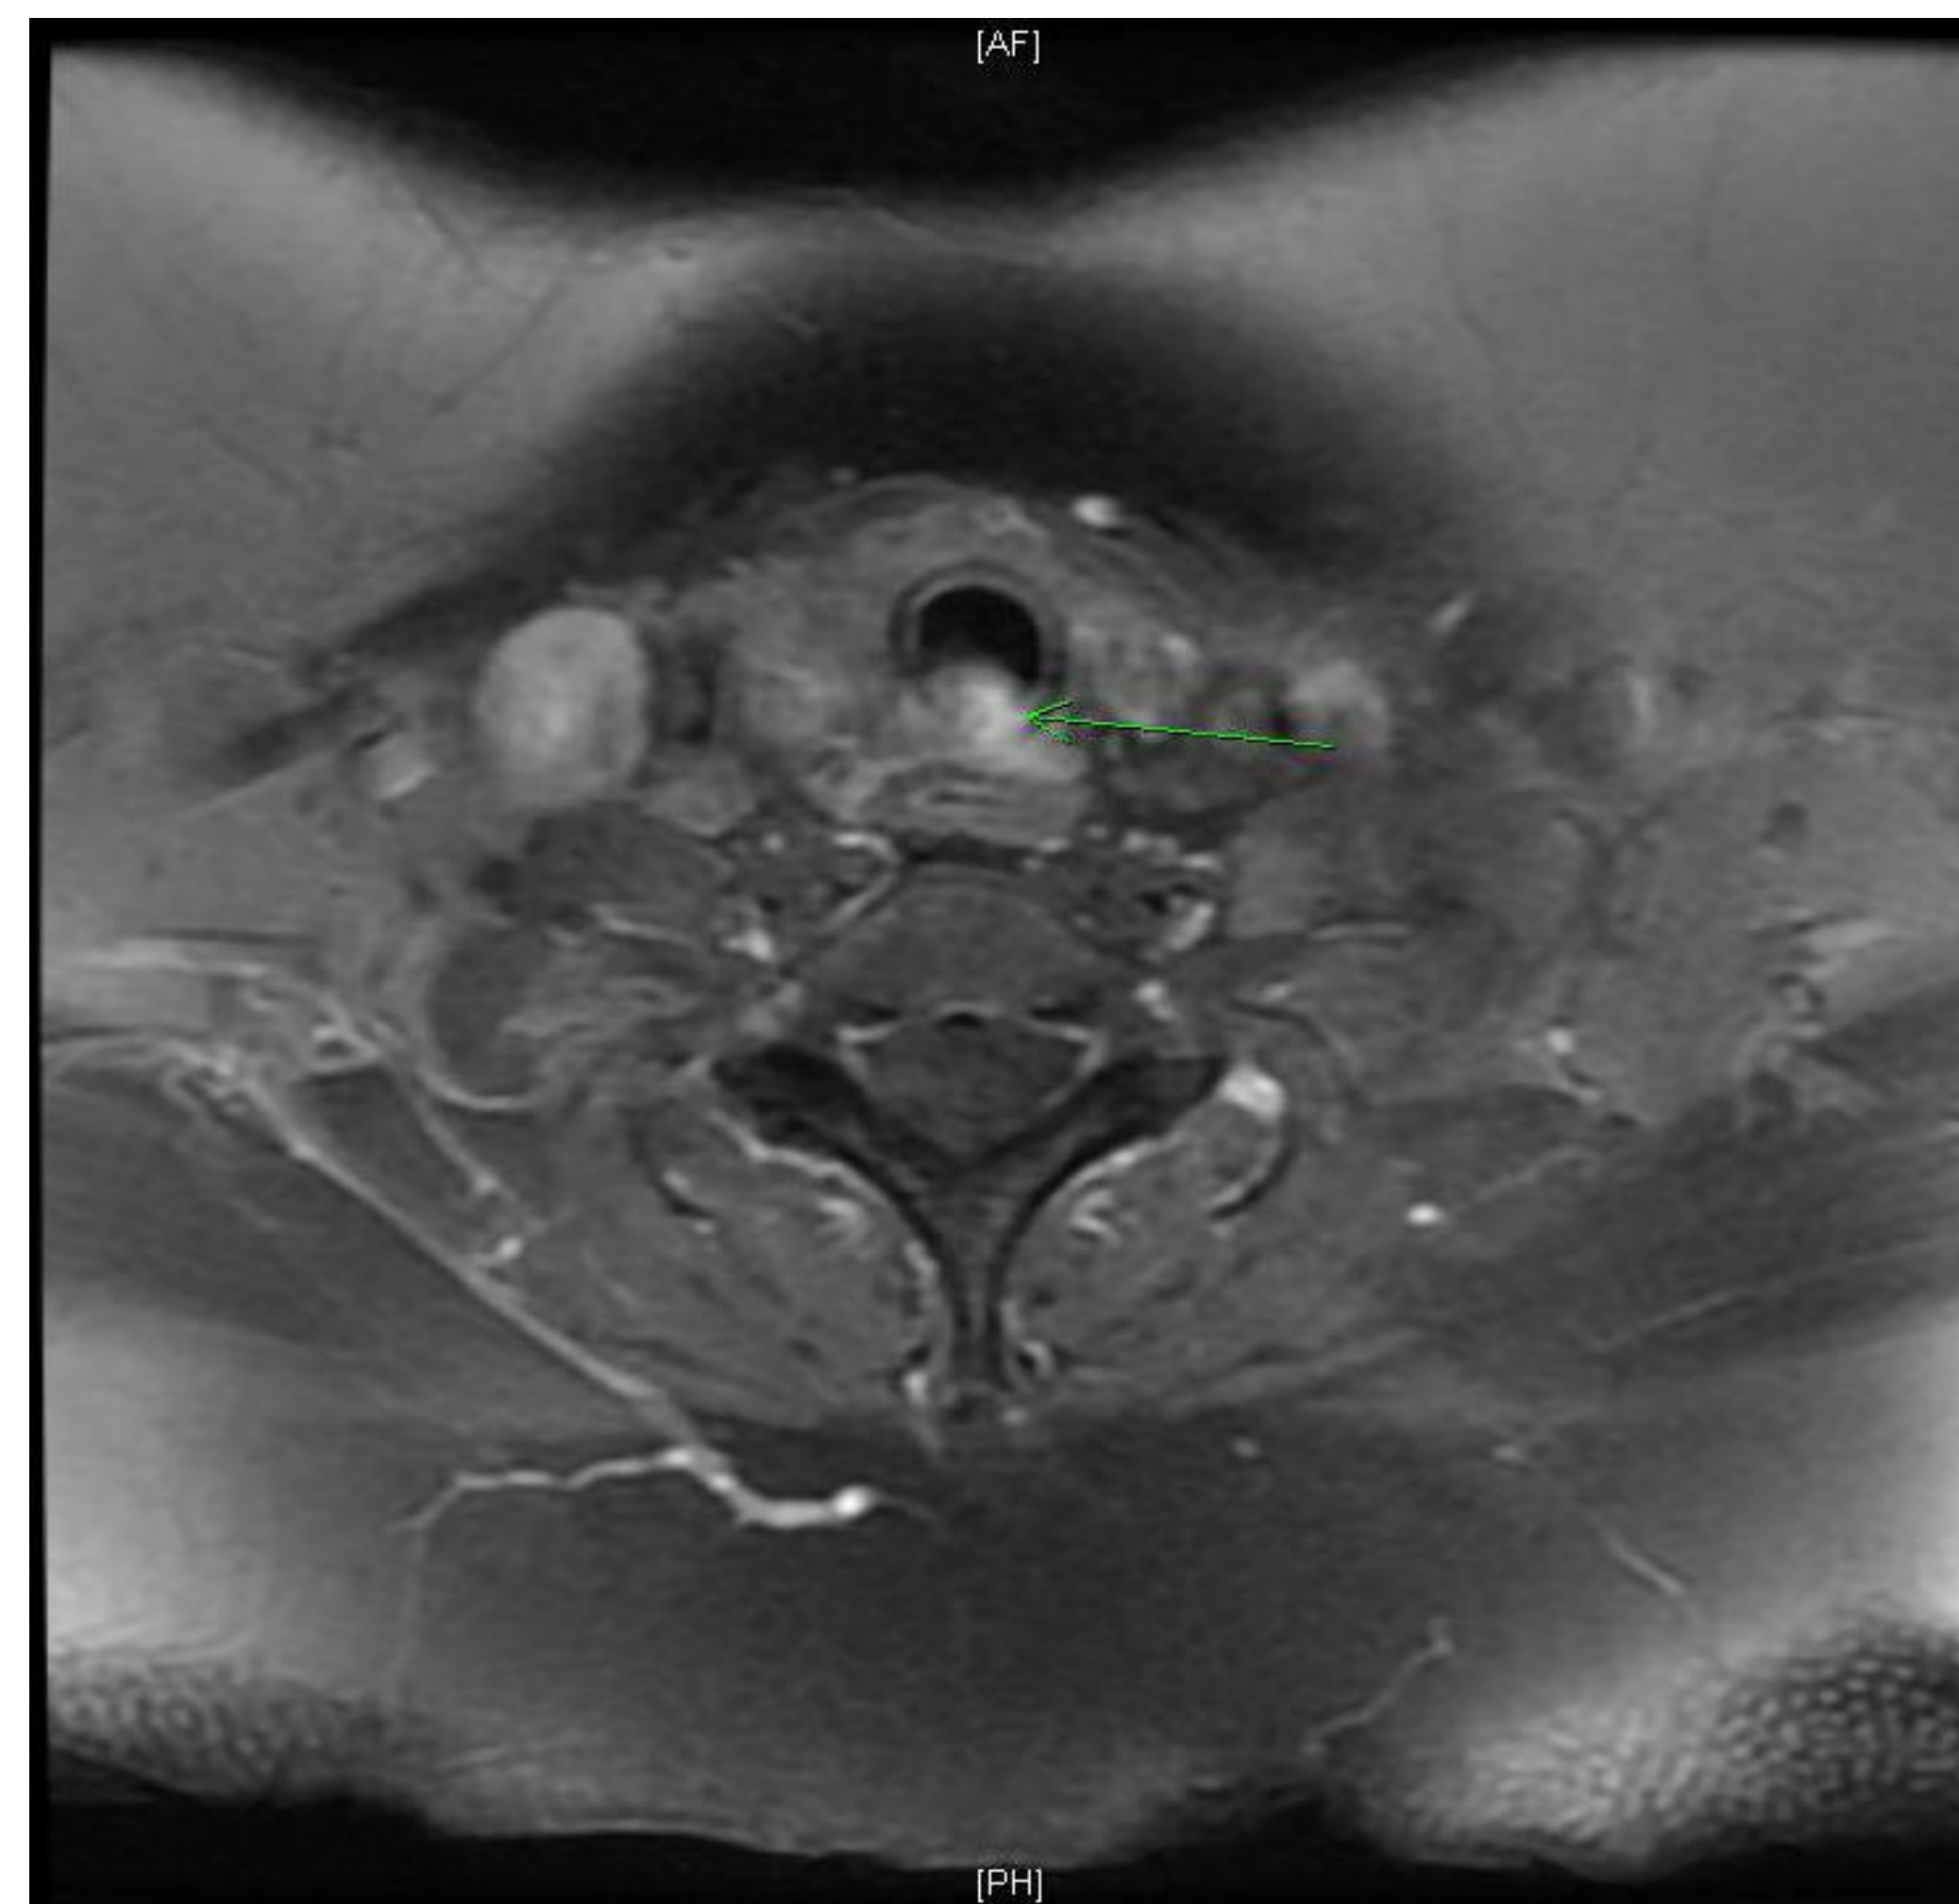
MRI of the neck; enlarged heterogeneous thyroid encircling proximal trachea contiguous with mass projecting into the posterior aspect of the trachea.
